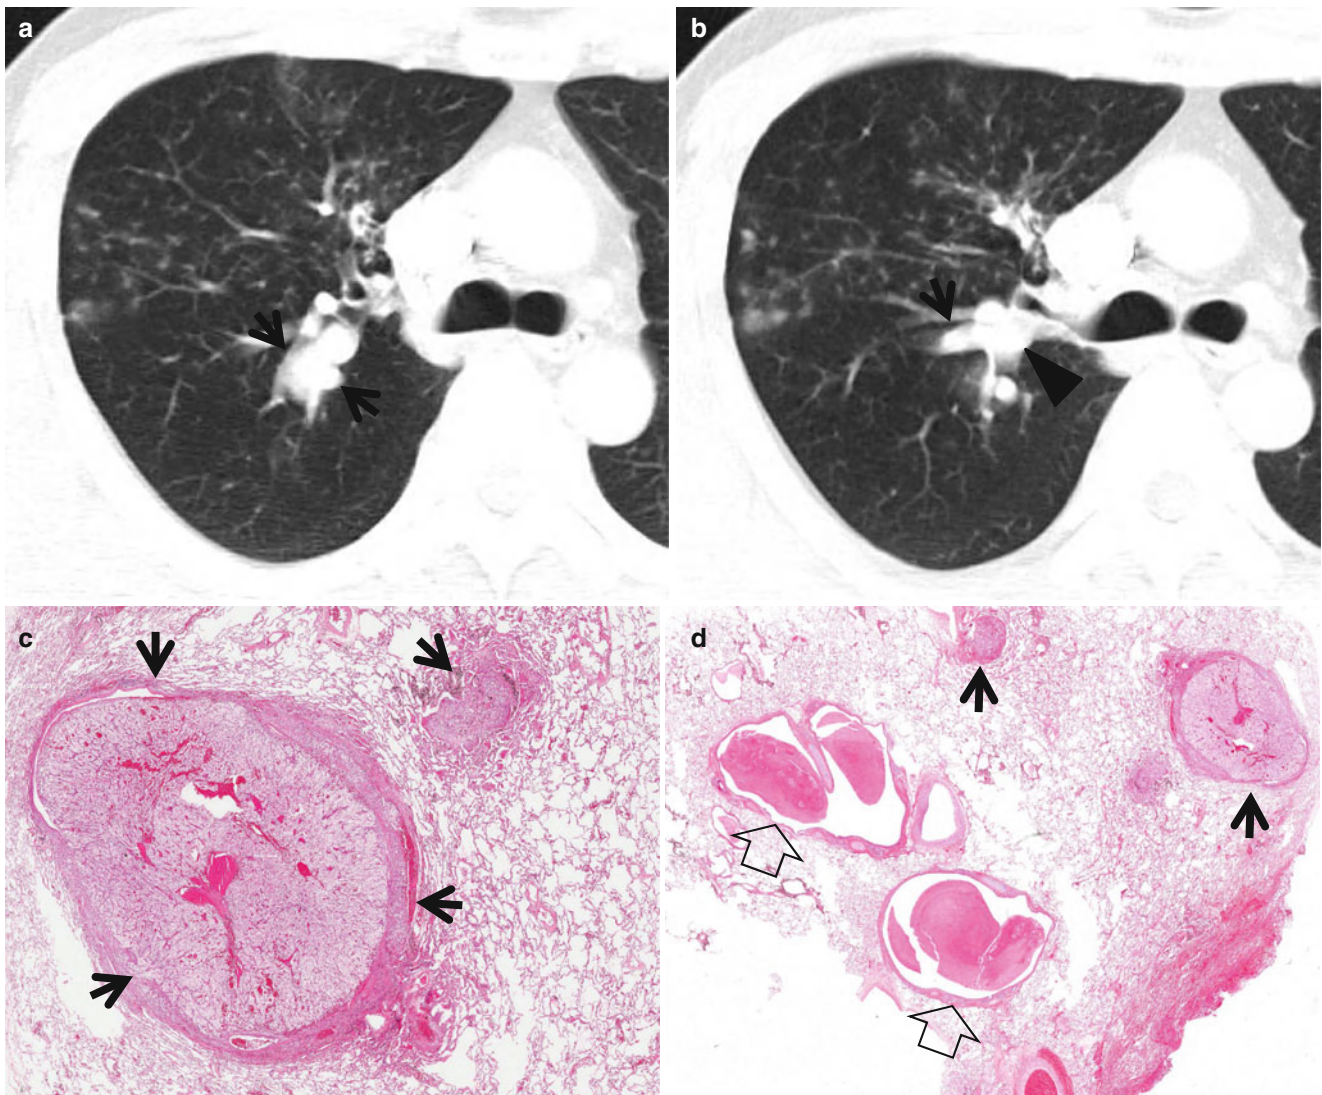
Gloved finger sign associated with mucus retention in airways distal to endobronchial metastasis in a 54-year-old man with renal cell carcinoma. (a, b) Lung window images of CT scans (5.0-mm section thickness) obtained at levels of the azygos arch (a) and main bronchi (b), respectively, show branching tubular lesions (arrows) in posterior segment of the right upper lobe, representing mucus plugging. Also note endobronchial tumor (arrowhead) in the posterior segmental bronchus of the right upper lobe. Bronchoscopic biopsy disclosed endobronchial metastatic renal cell carcinoma nodule (not shown here).
